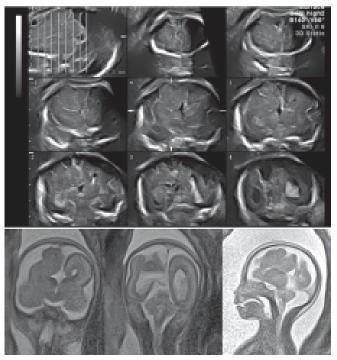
Migration disorder at 18 weeks of gestation. (upper) Tomographic coronal image of the brain. Note the different development between bilateral hemispheres. (lower) MR images. Anterior-coronal, posterior-coronal and sagittal sections from the left. Unilateral abnormal brain development was caused according to migration disorder
